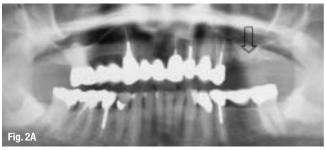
2A_A preoperative panoramic radiograph showing ~3 mm subantral bone height in the location of the former upper left first molar (arrow).
